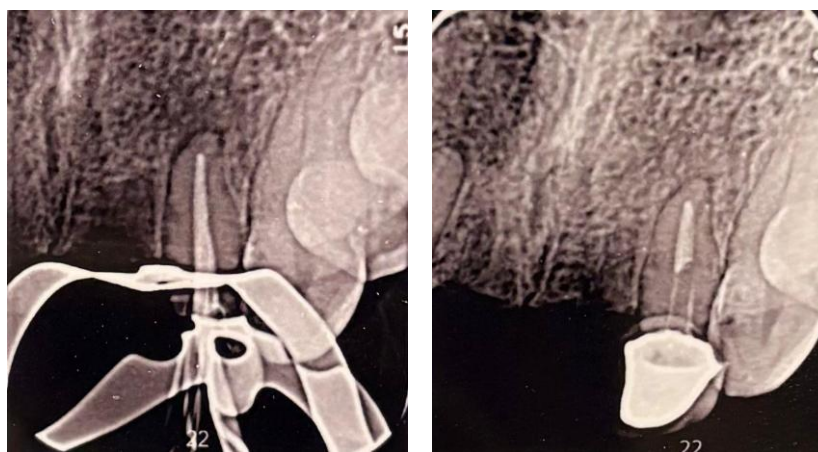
Figure B and Figure C. Post-dental obturation radiography 22 and 3-month follow-up with MJ peg restoration
